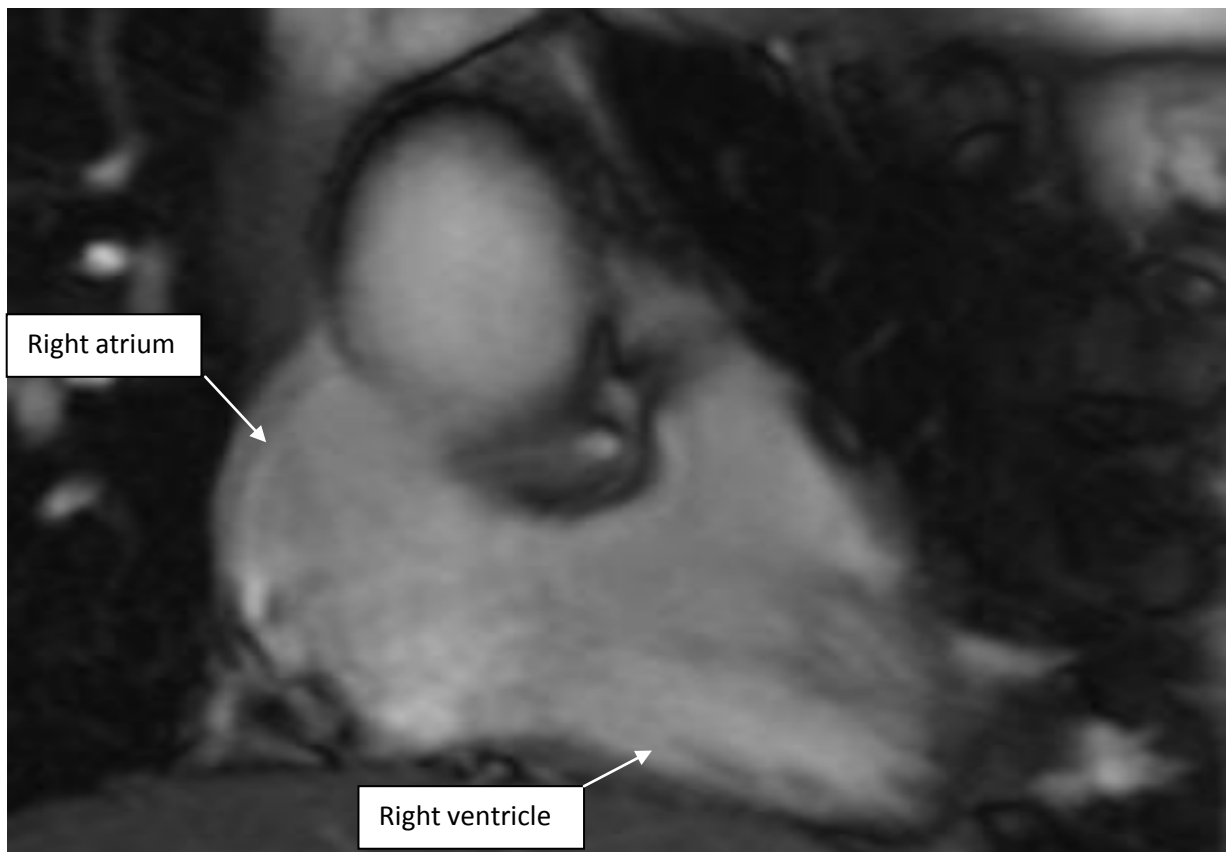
MRI CINE two chamber view (vertical long axis view) of right ventricle at systole
